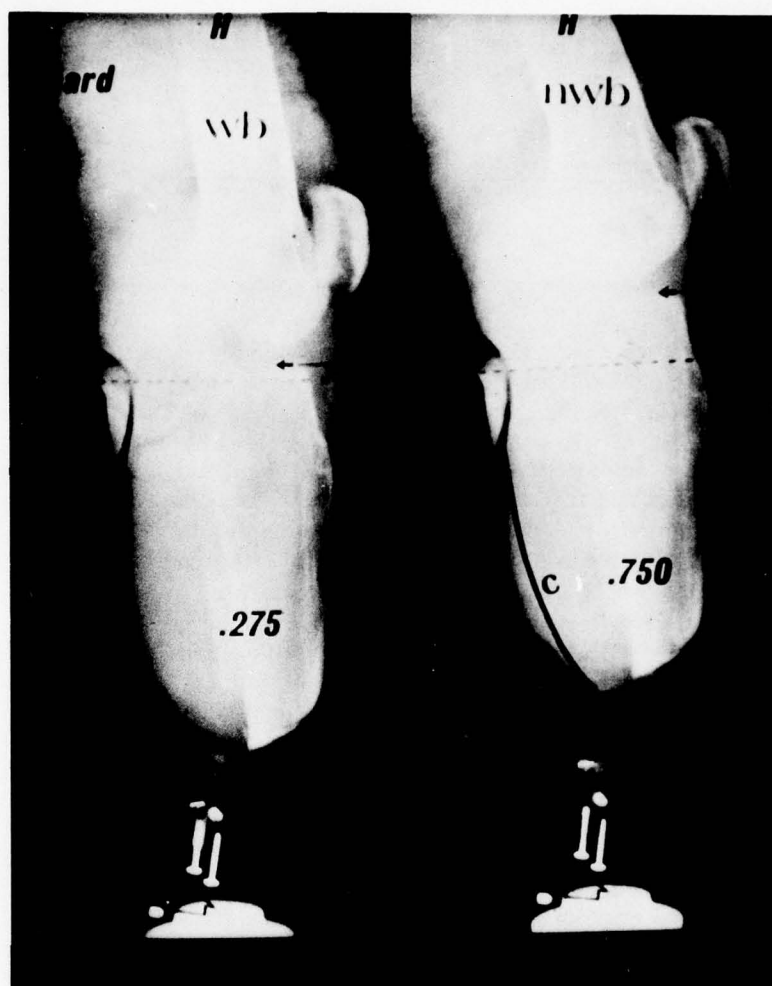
X-rays of patient No. 4: at left, weight-bearing and at right, non-weight-bearing, revealing displacement in contracted position.
